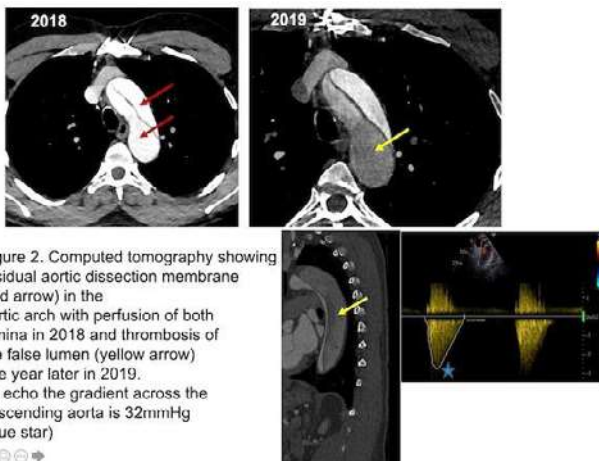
Computed tomography showing residual aortic dissection membrane (red arrow) in the aortic arch with perfusion of both lumina in 2018 and thrombosis of the false lumen (yellow arrow) one year later in 2019. By echo the gradient across the descending aorta is 32mmHg (blue star)
